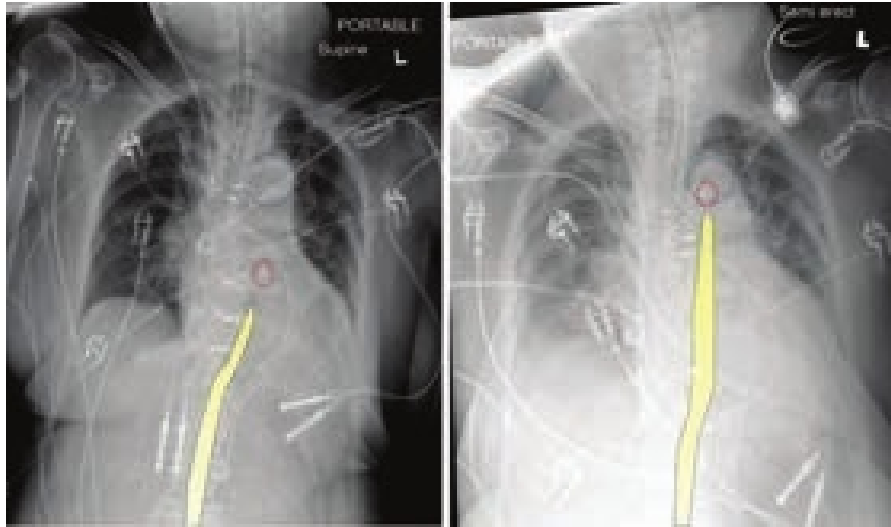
Verifying proper placement of intraaortic balloon pump (IABP). The blue circles in each image represent the aortic knob in a semiupright portable chest x-ray. The red circle identifies the radiopaque marker signifying the proximal end of the balloon that should be within 2 cm of the aortic knob. The balloon can be seen inflated and is outlined by the yellow shape. The left image shows the balloon too distal, potentially obstructing visceral vessels. The image on the right shows the balloon's proximal marker slightly too high, likely at the level of the left subclavian origin.
